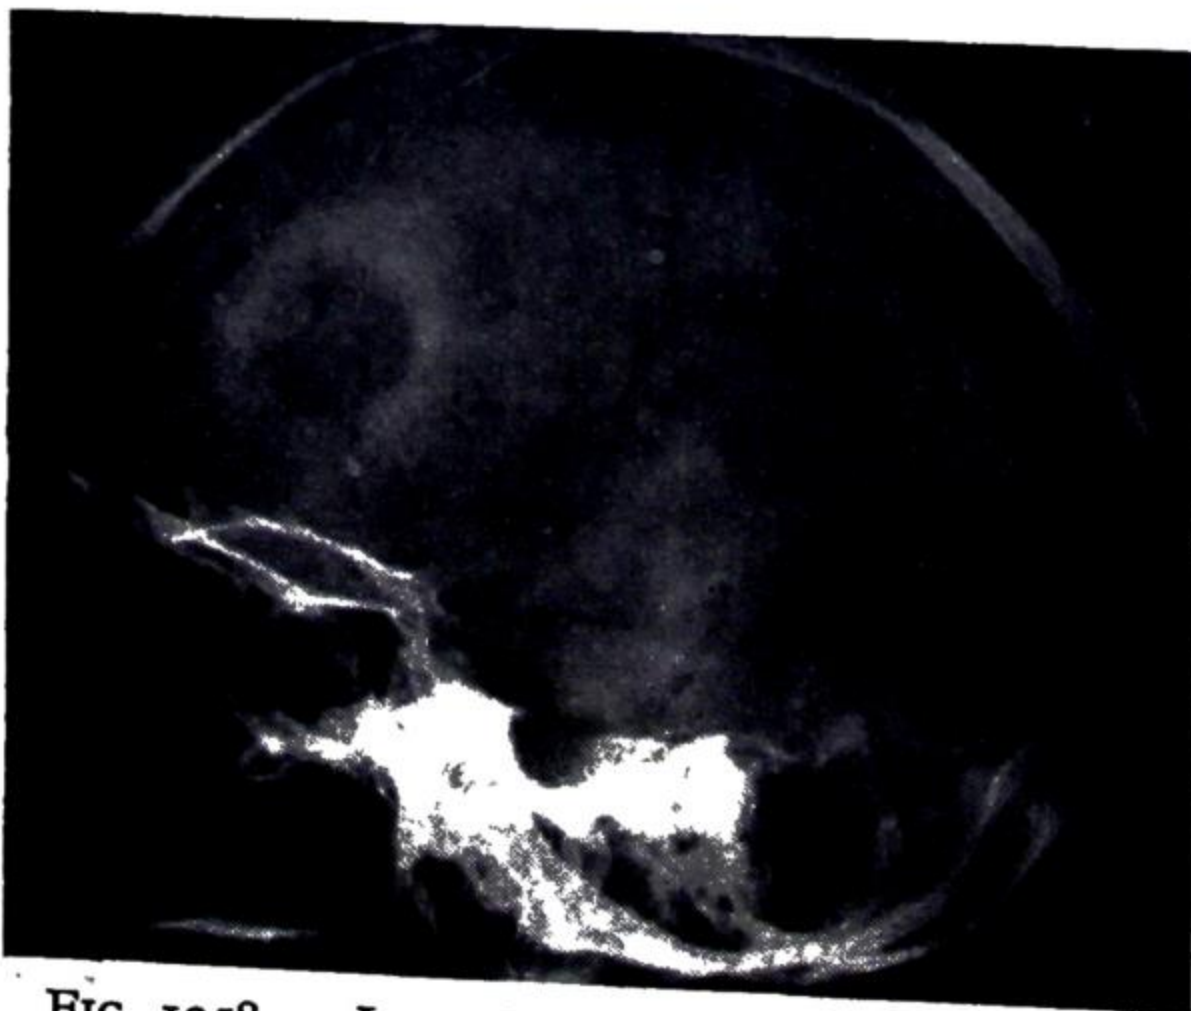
Lateral X-ray showing irregular clear area produced by a malignant secondary deposit from carcinoma of the breast.
